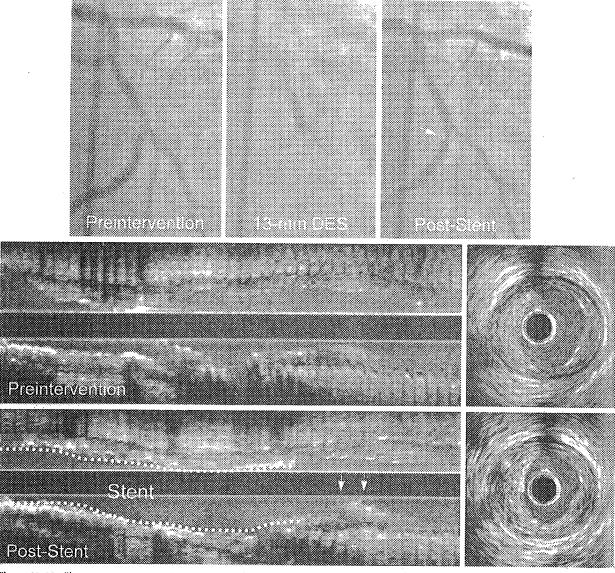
Plaque extrusion occurring as a result of stenting. The coronary angiogram taken immediately after stenting showed a new stenosis (arrow) at the distal adjacent segment to the implanted stent. Although spasm, dissection, and/or hematoma was suspected by angiography, intravascular ultrasound (IVUS) revealed that the secondary lesion was caused by a significant plaque increase (arrows), presumably resulting from axial plaque redistribution, otherwise known as "plaque shift" from the stented segment into this region.
